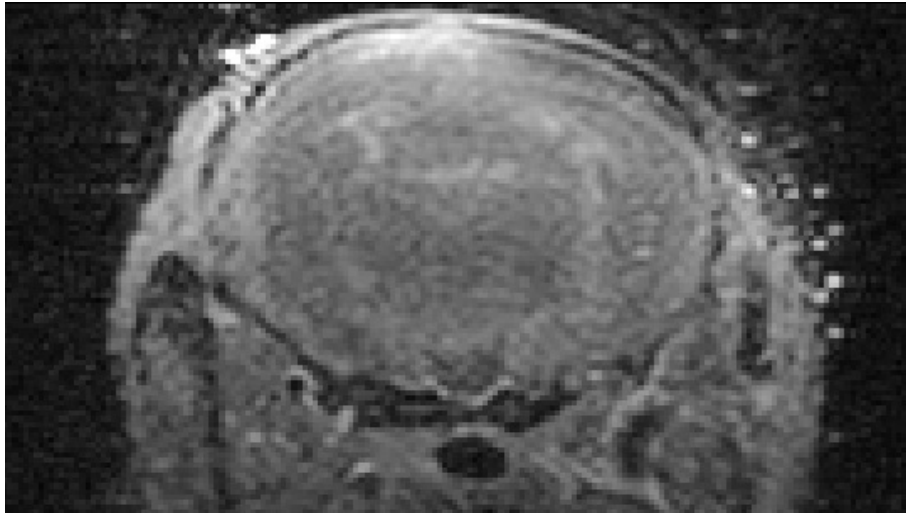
Motion artefact of the  $b = 0$ . First time-point of the DWI in the *ex vivo* acquisition protocol. Coronal section, subject 4302.
